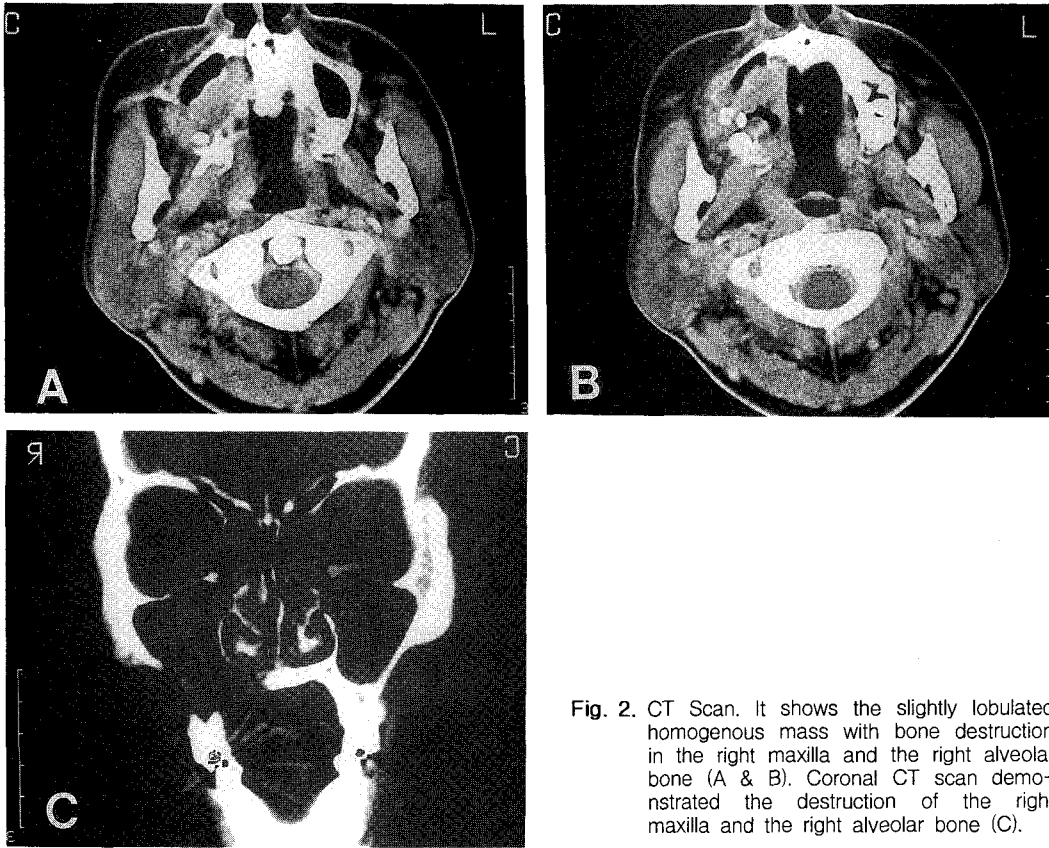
CT Scan. It shows the slightly lobulated homogenous mass with bone destruction in the right maxilla and the right alveolar bone (A & B). Coronal CT scan demonstrated the destruction of the right maxilla and the right alveolar bone (C).
